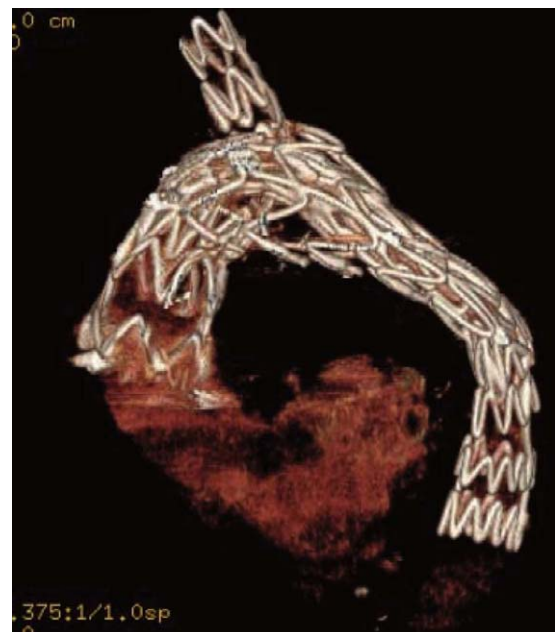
Computed tomography angiography shows the skeletal structure of the bifurcated stent graft.
